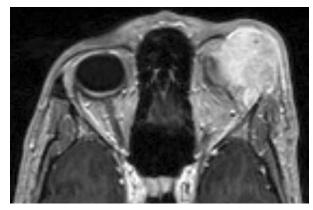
MRI demonstrates a mass involving the frontal bone at the lateral superior aspect of the orbit, extending superiorly in the frontal bone.
